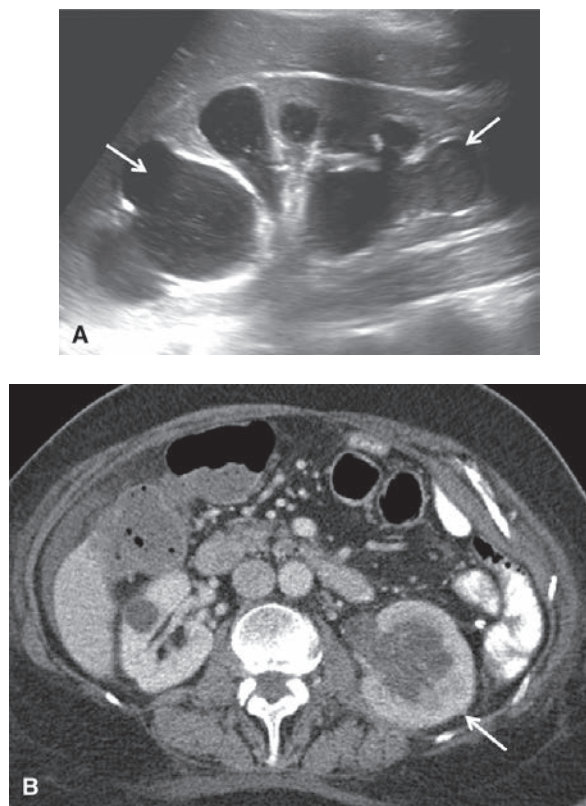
A 48-year-old woman with cervical cancer presents with left flank pain and fever: A: Sagittal gray-scale ultrasound image of the left kidney demonstrates marked hydronephrosis compatible with ureteral obstruction secondary to the patient's cervical neoplasm. There is echogenic debris present in the dilated collecting system (arrows) compatible with pus in the setting of pyonephrosis. B: Axial contrast-enhanced CT scan in the same patient demonstrates the enlarged left kidney with hydronephrosis (arrow). There is a delayed nephrogram compared with the right, compatible with obstruction. The left nephrogram is also heterogeneous and there is perinephric inflammatory change compatible with pyelonephritis. The right kidney is normal with the exception of a small cyst.
